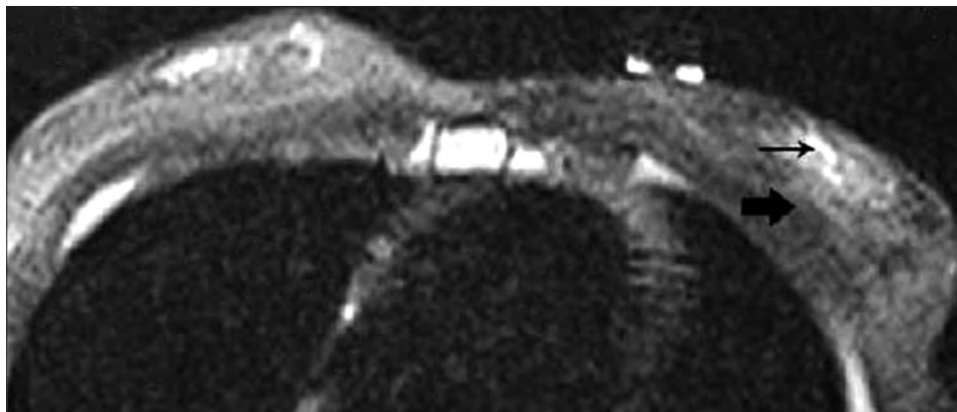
An axial SPIR MR image showing fat tissue with low signal intensity (*wide arrow*) and glandular breast tissue with intermediate signal (*narrow arrow*).
